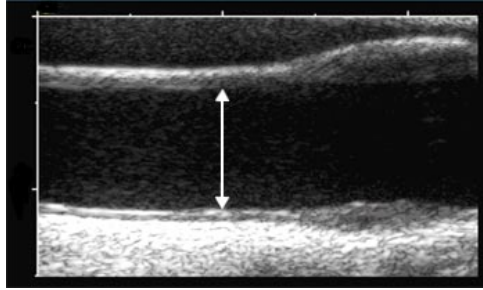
Diameter of the artery measured by ultrasound.
